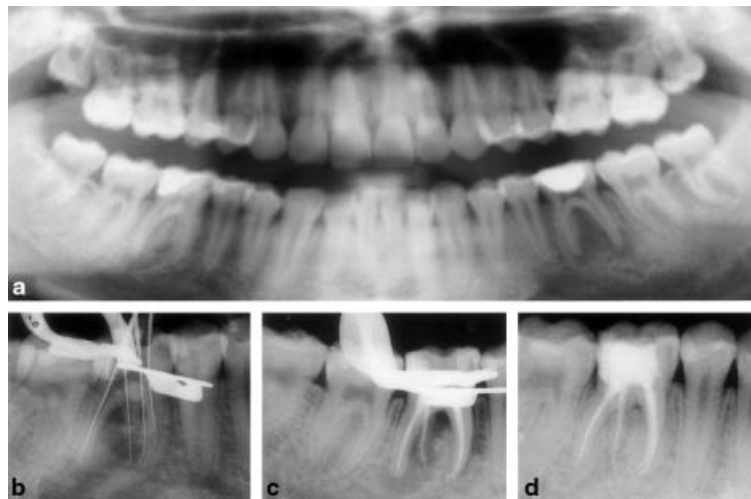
(a) Panoramic radiograph showing tooth 36 with an extensive coronal restoration and periapical radiolucency; and tooth 46 with a class II restoration and periapical radiolucency. (b) Length-determination radiograph (tooth 46) of the conventional root canals (one distal root canal and two mesial canals) and the root canal of the radix entomolaris. (c) Radiographic control following obturation of the four root canals. (d) One-year postoperative radiographic control indicating healthy apical bone structure with no radiographic signs of apical periodontitis.
